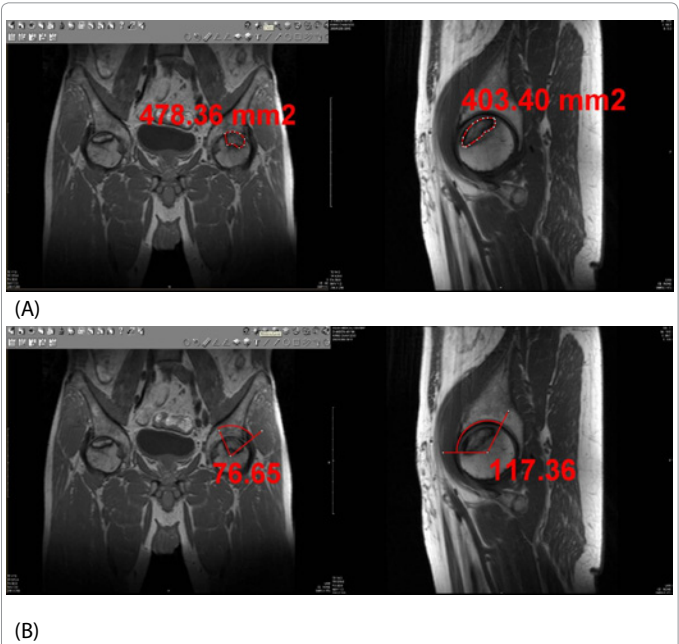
48-year-old male with osteonecrosis of the both femoral heads. To check amount of osteonecrosis we evaluated T1-weighted coronal and sagittal MR image. (A) Absolute value of the osteonecrosis was evaluated by the tool measuring size in the PACS. (B) Necrotic angle of the osteonecrosis was evaluated by the tool measuring angle in the PACS.
